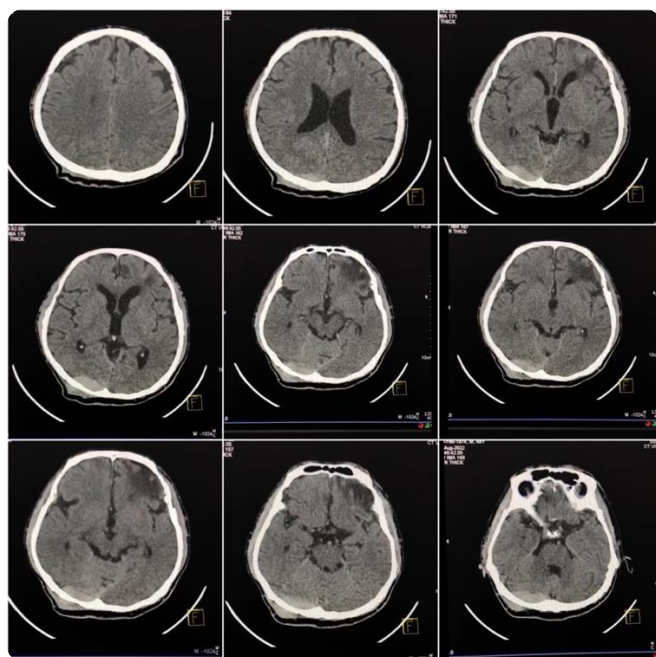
Head CT scan showed a chronic hypodense lesion in the left frontal region and acute EDH in the right occipital region.
